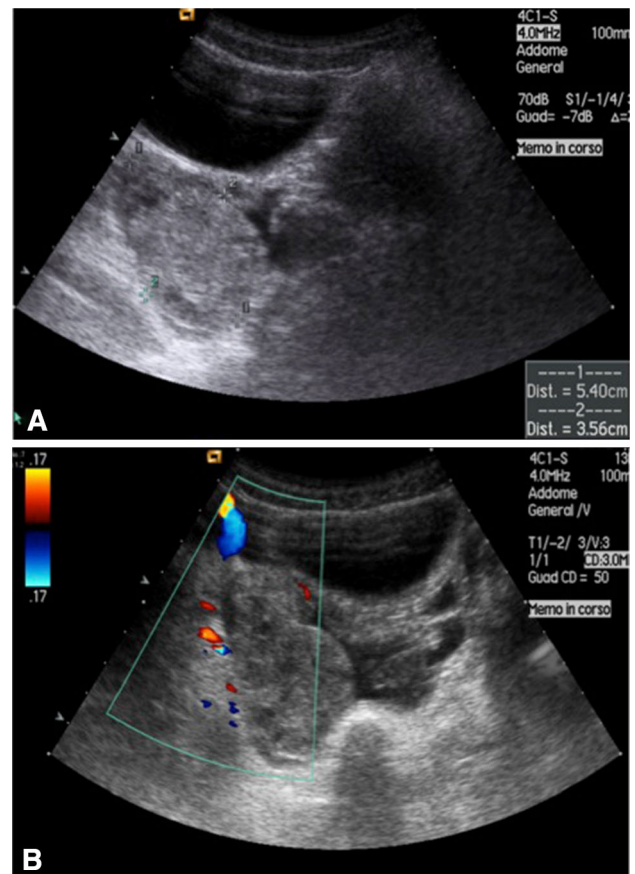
Ovarian torsion. a Transabdominal sonogram showing a large, heterogeneous, left adnexa containing multiple small cystic spaces along its periphery. There is also free fluid surrounding the adnexa. b Color Doppler sonogram showing absent arterial and venous flow in the ovarian tissue
